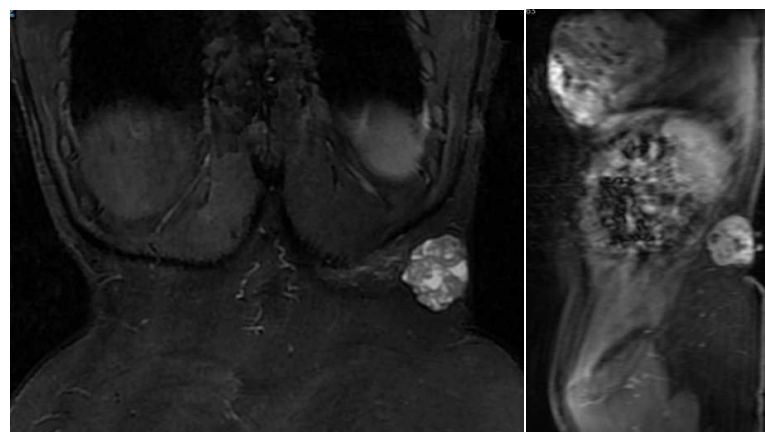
Coronal STIR and Figure 3: Sagittal T1 contrast-enhanced MRI showing a soft tissue tumor located in the subcutaneous cellular tissue of the left paravertebral region, measuring 4.4 cm at its greatest diameter, with no signs of adjacent fascial infiltration (T1a). The lesion demonstrates heterogeneous contrast enhancement with areas of necrotic and cystic degeneration, suggestive of sarcoma.
